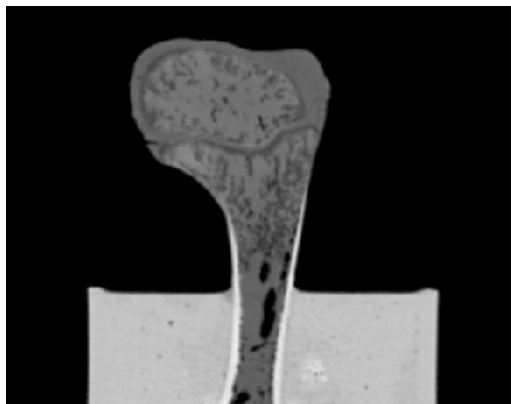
CT image of the femur and its mounting jig.
